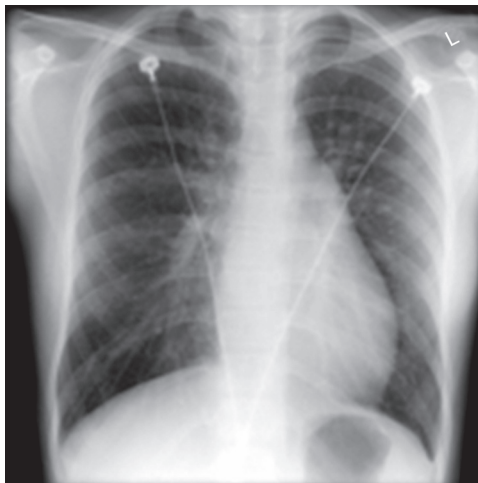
Chest X-ray in atrial septal defects showing prominent pulmonary artery and pulmonary congestion in upper lobes
